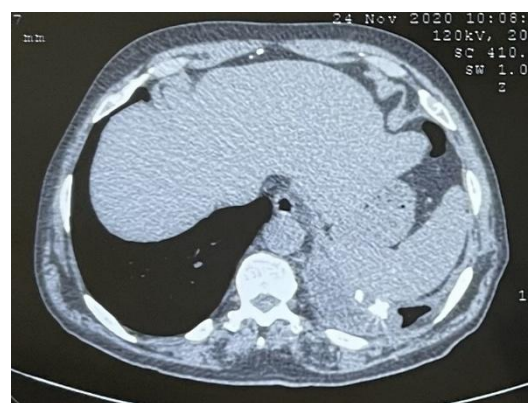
Contrast-enhanced computed tomography chest showing metallic foreign body in the left pleural cavity near the diaphragm.
